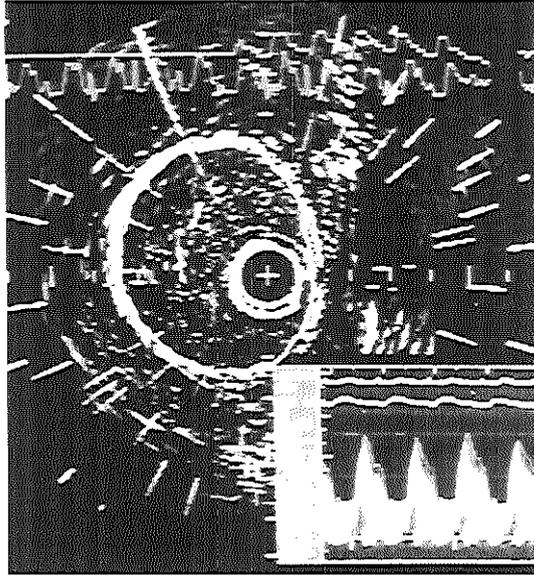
Intravascular ultrasound cross-section of a proximal normal left circumflex artery 6 months after cardiac transplantation. The simultaneous recording in the same position of flow velocity with a Doppler guidewire (Cardiometrics, CA, USA) allows the calculation of the instantaneous absolute flow. Calibrations: intravascular ultrasound = 1 mm; Doppler = 120 cm/s.
